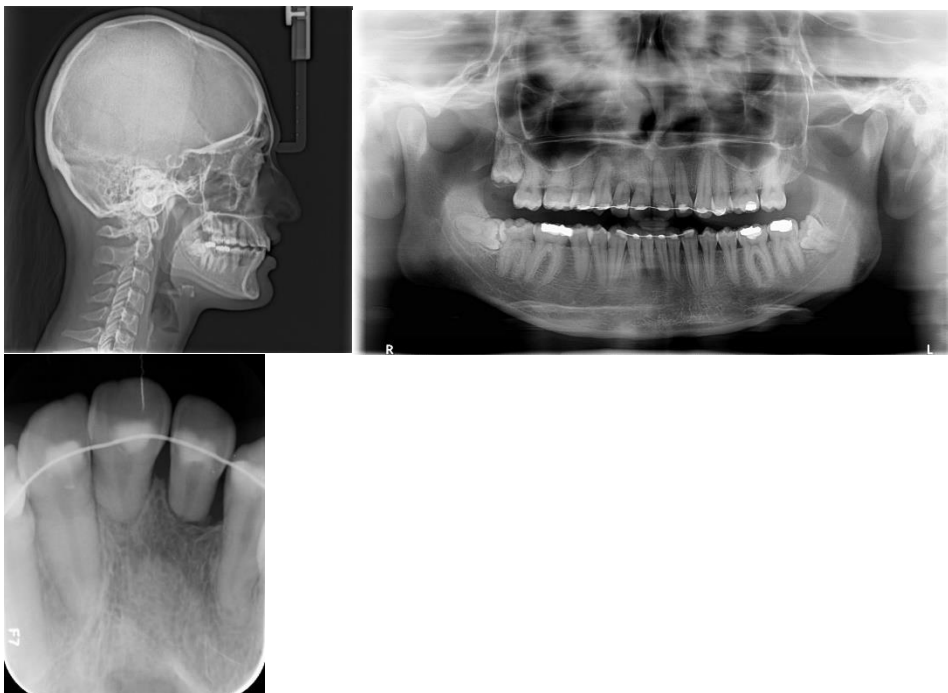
Final lateral cephalometric radiograph, panoramic radiograph and periapical radiograph.
